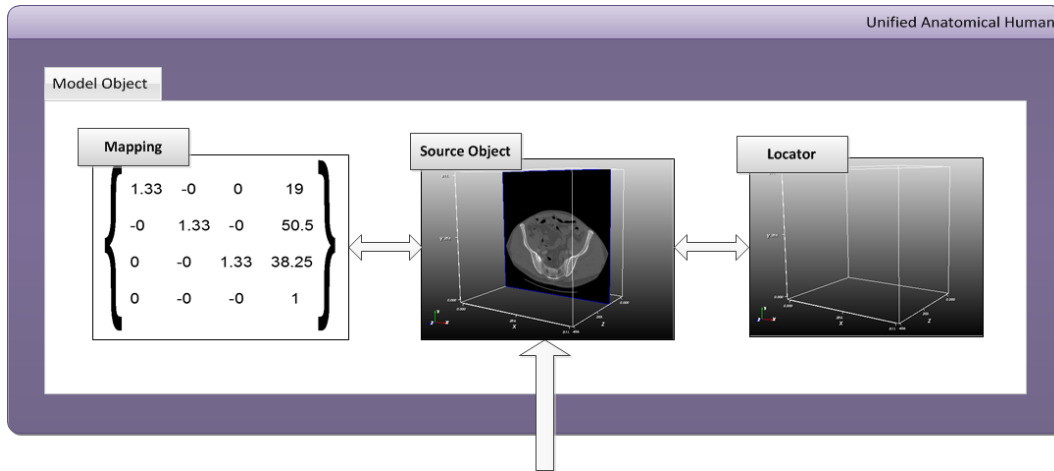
This figure demonstrates the process of adding a patient-specific CT scan to the Unified Anatomical Human model.
